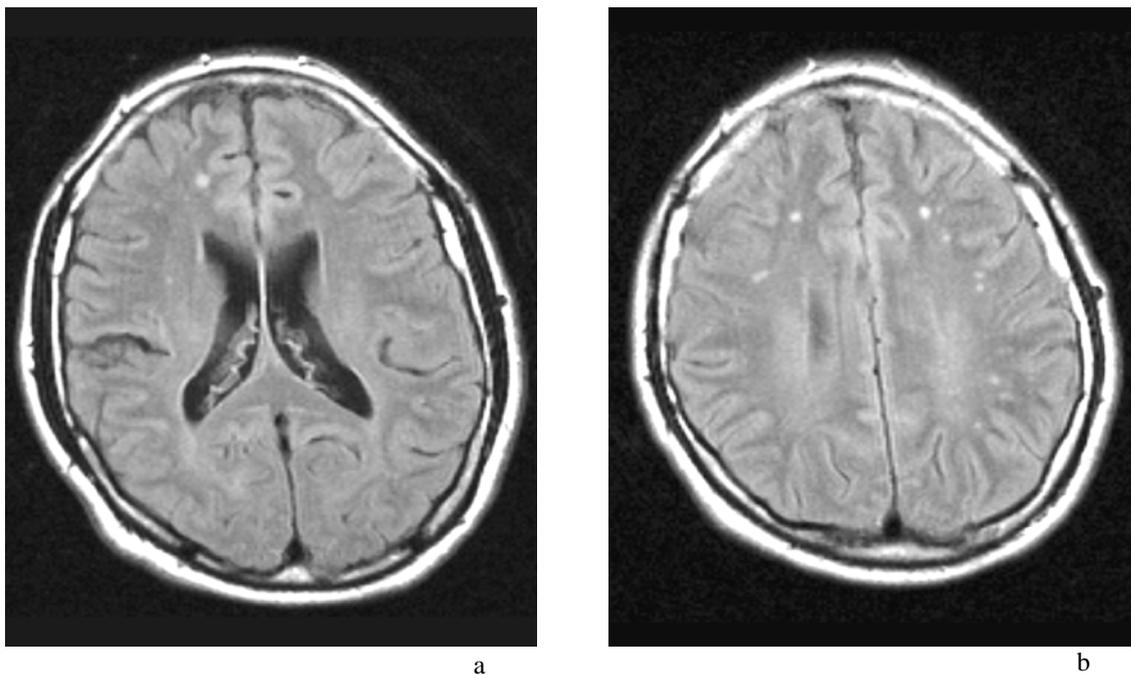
T2-weighted FLAIR images of a 41 years old male who suffered a mild traumatic brain injury four years previously and who presented with neurocognitive complaints. Bilateral focal areas with increased signal are seen in the frontal white matter as well as in the left parietal white matter. The T2-weighted gradient-echo images (not shown) did not reveal focal signal loss, there is no haemosider deposition.
